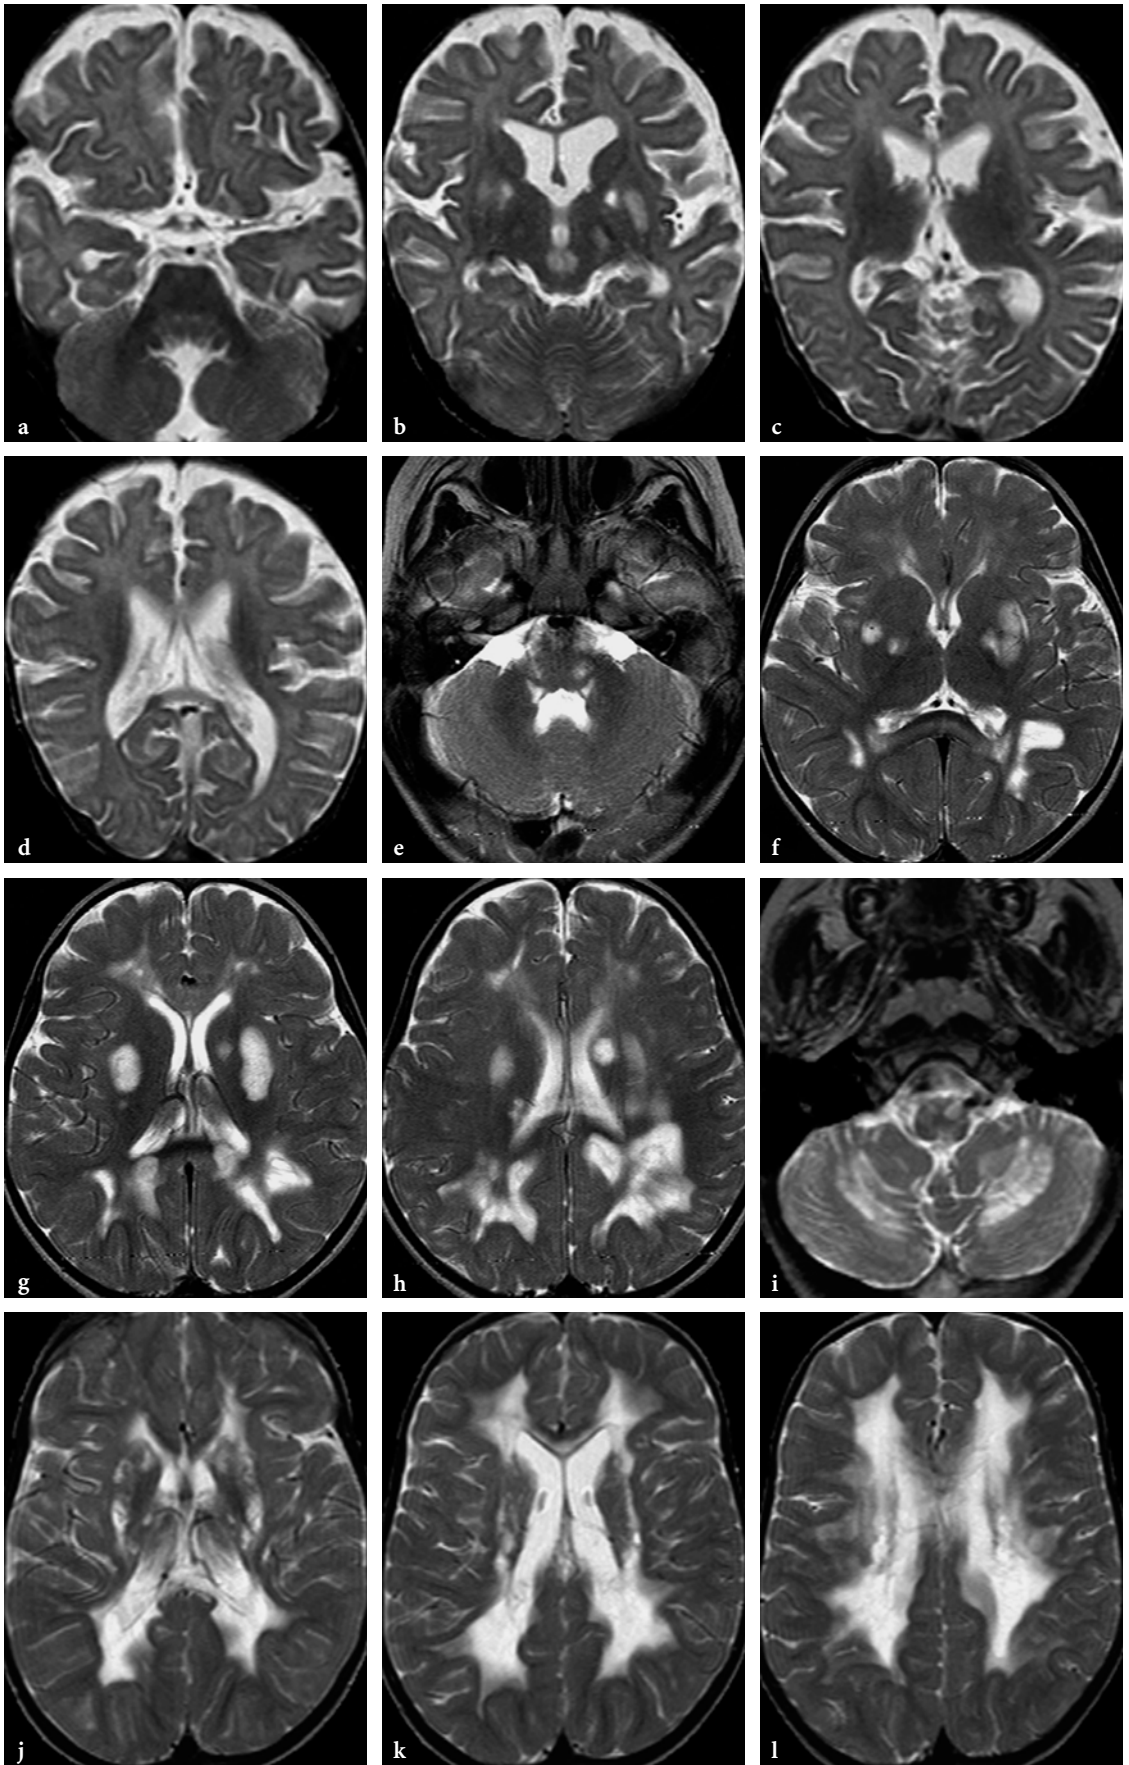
Different conventional MR imaging patterns in Leigh disease on axial modular inversion recovery images. a-d 3-year-old female patient. Abnormal signal intensities are seen within inferior olives, dentate nuclei, fasciculus longitudinalis medialis, central tegmental tracts, putamina and globus pallidus on the left side. e-h 2-year-old male patient. The pattern is very much similar to that of the previous patient, except that here the basal ganglia are normal. At the level of mesencephalon, the medial lemnisci and the substantia nigra are also involved
